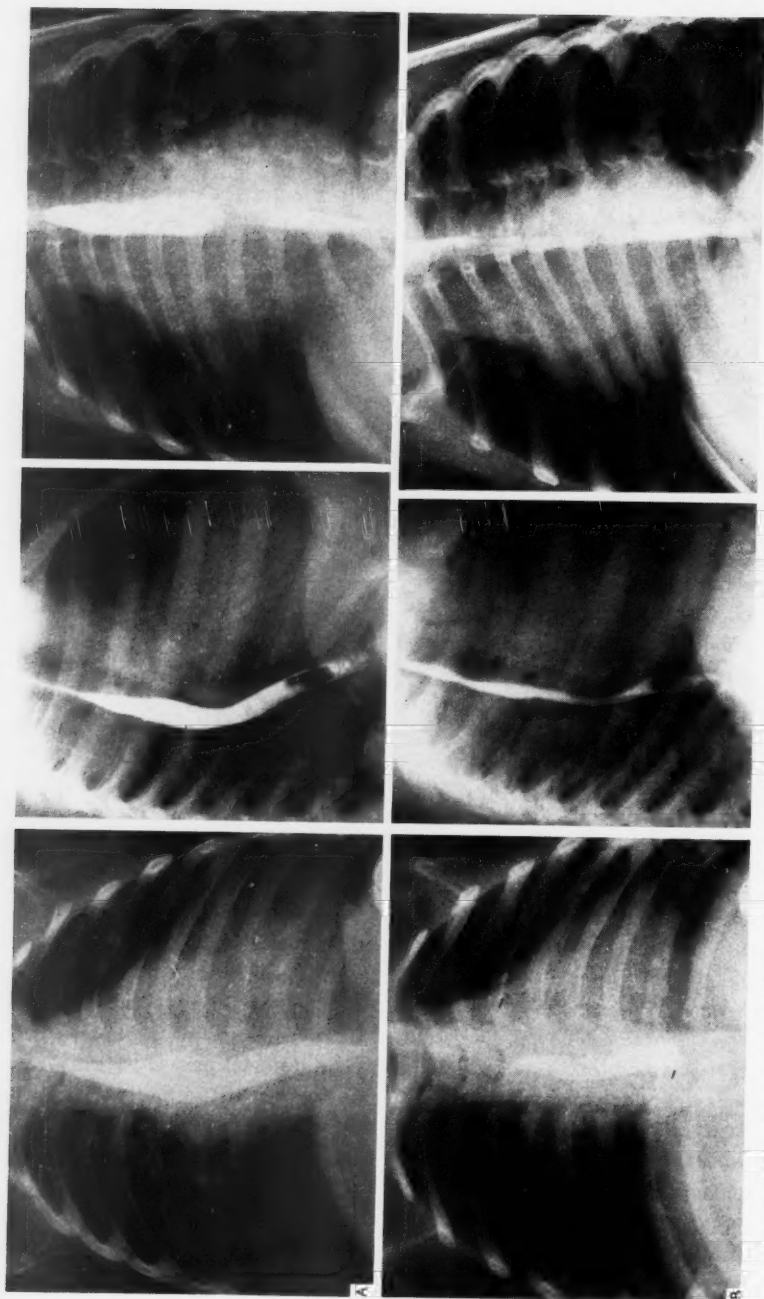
X-ray of heart. (A) before and (B) 6 months after operation. Relative cardiac volume 400 and 200 cc respectively (Case 13).
